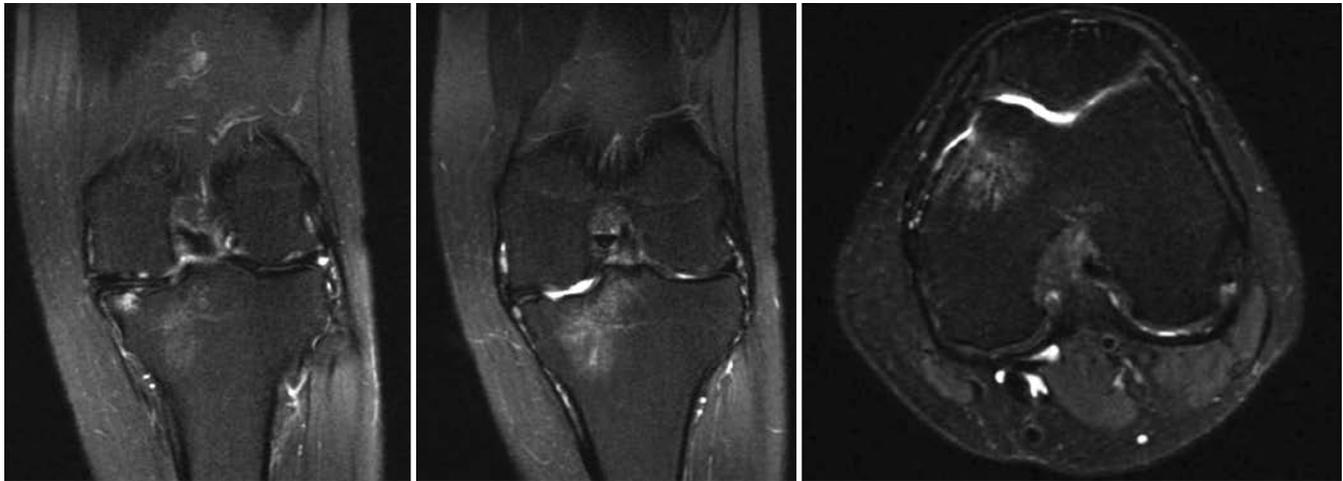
Noncontrast MRI of the left knee taken prior to cartilage restoration, following a series of 9 prior surgeries, demonstrating flattening of the medial femoral condyle associated with medial compartment joint space narrowing and mild medial tibial plateau osteophyte formation; also appreciated is a full-thickness posterior medial femoral condyle defect and associated bone marrow edema in the proximal medial tibial plateau and medial femoral condyle.
